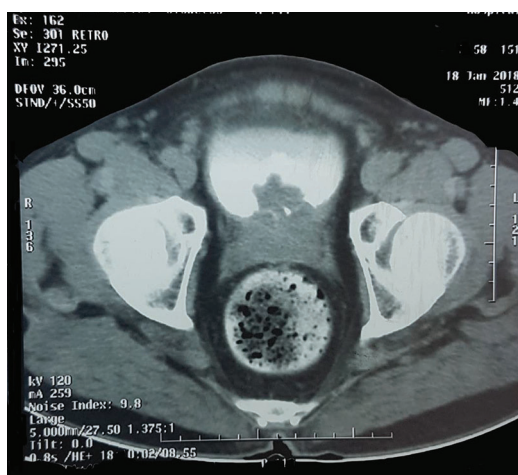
CT Abdomen - Pelvis
